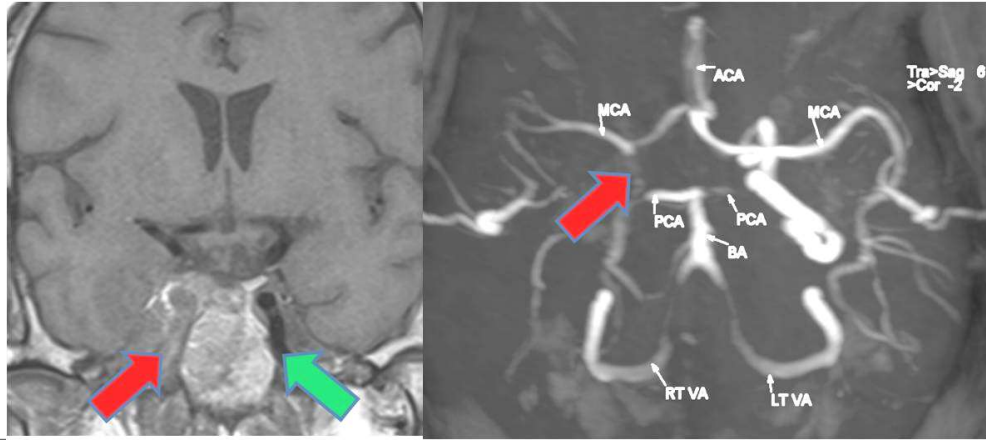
a/b/c: Right ICA occlusion: T1W coronal image show no flow void at right ICA at precavernous/cavernous segment (Red arrow); compare with normal left side. MR angiography show no flow signal at right ICA (Red arrow). Note the extensive right MCA territory infarct at right brain on DWI images (blue arrows).
